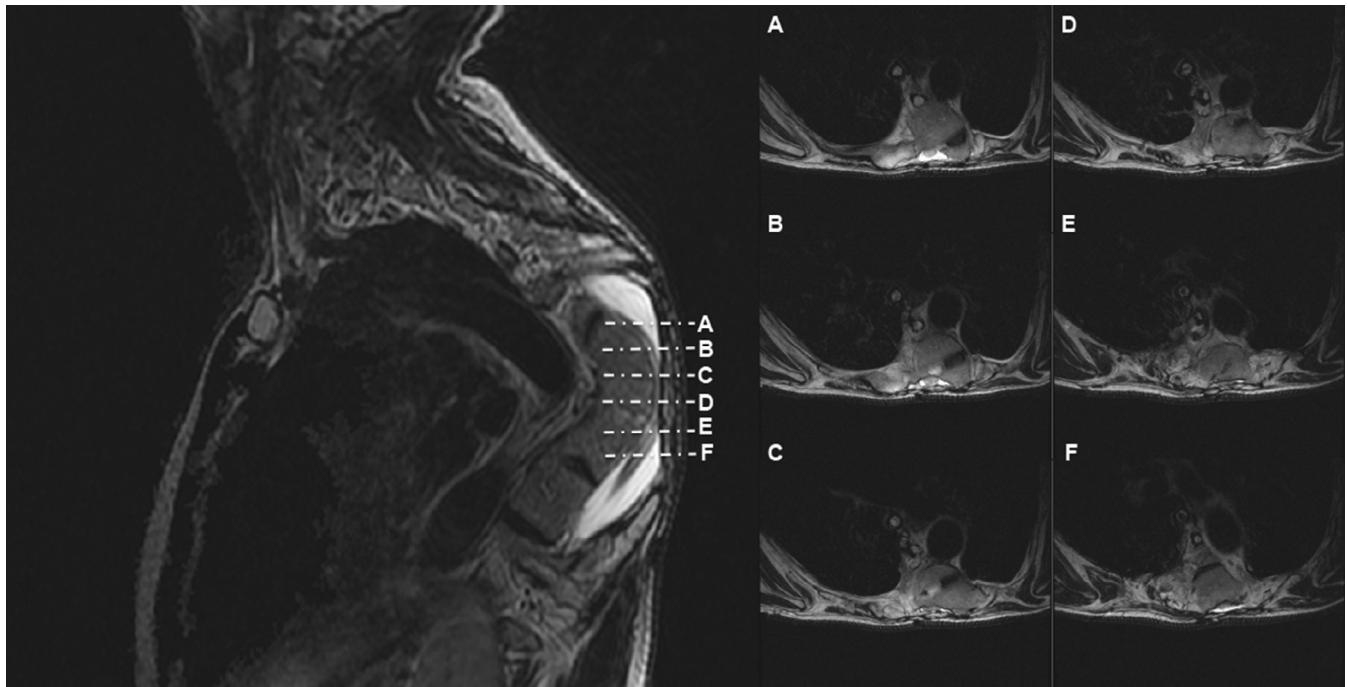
MRI T2-weighted thoracic spine: sagittal level related to axial views (A–F) revealing extrinsic compression, spinal cord standing directly below soft tissues was stable and merged after 5 years.
